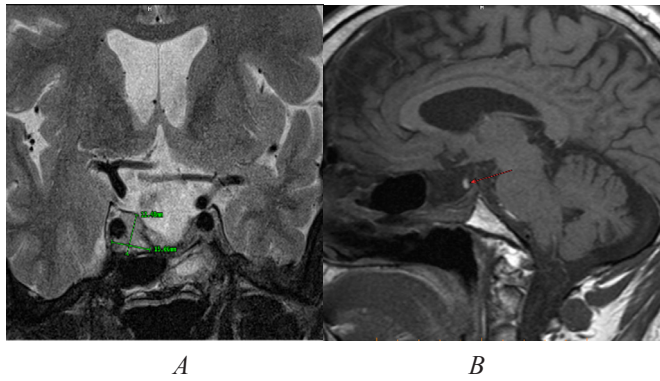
Post-operative MRI findings after extirpation of pituitary macroadenoma by the transsphenoidal route. A) Solid remnant about 15 x 12 mm near the right ACL extending to the lateral intercarotid line. The suprasellar space, including the optic chiasm, is completely free. The signal from the internal carotid arteries is normal; B) T1 hyperintensity of the neurohypophysis appears parasagittal to the left (red arrow); C) Pituitary fossa remains enlarged in all directions.
